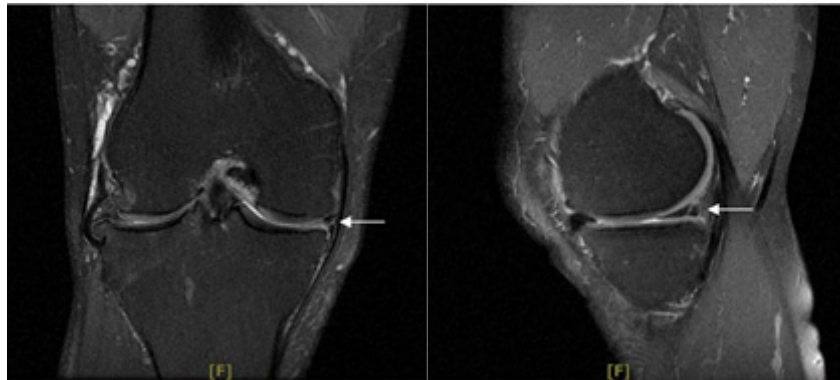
Right knee MRI from case 3(02/10/2020).
